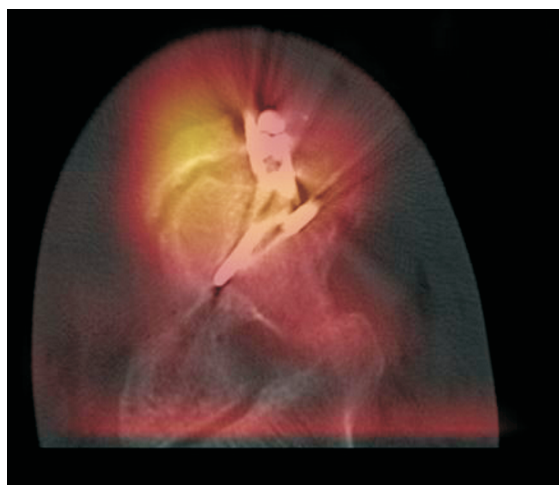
SPECT-CT imaging showing talonavicular joint fusion site.
